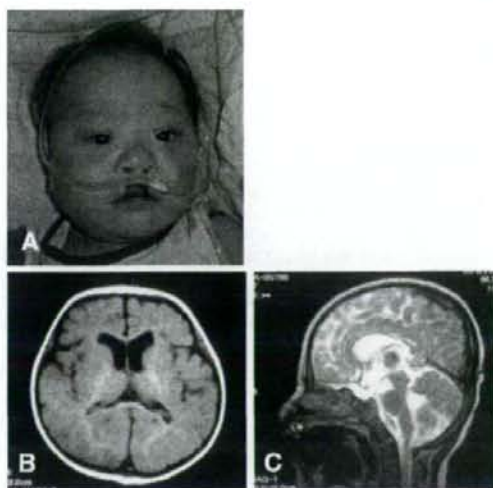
Facial expression of the patient (A). Dysmorphic appearance with prominent forehead, broad nasal bridge, upslanting palpebral fissures, and cleft lip is seen in a photograph taken when he was 12 months of age. Brain magnetic resonance image at 12 months old showing an axial section (B) and sagittal section (C). Mild delay of myelination, mild dilatation of the lateral ventricles and hypoplasia of the splenium of the corpus callosum are shown.
